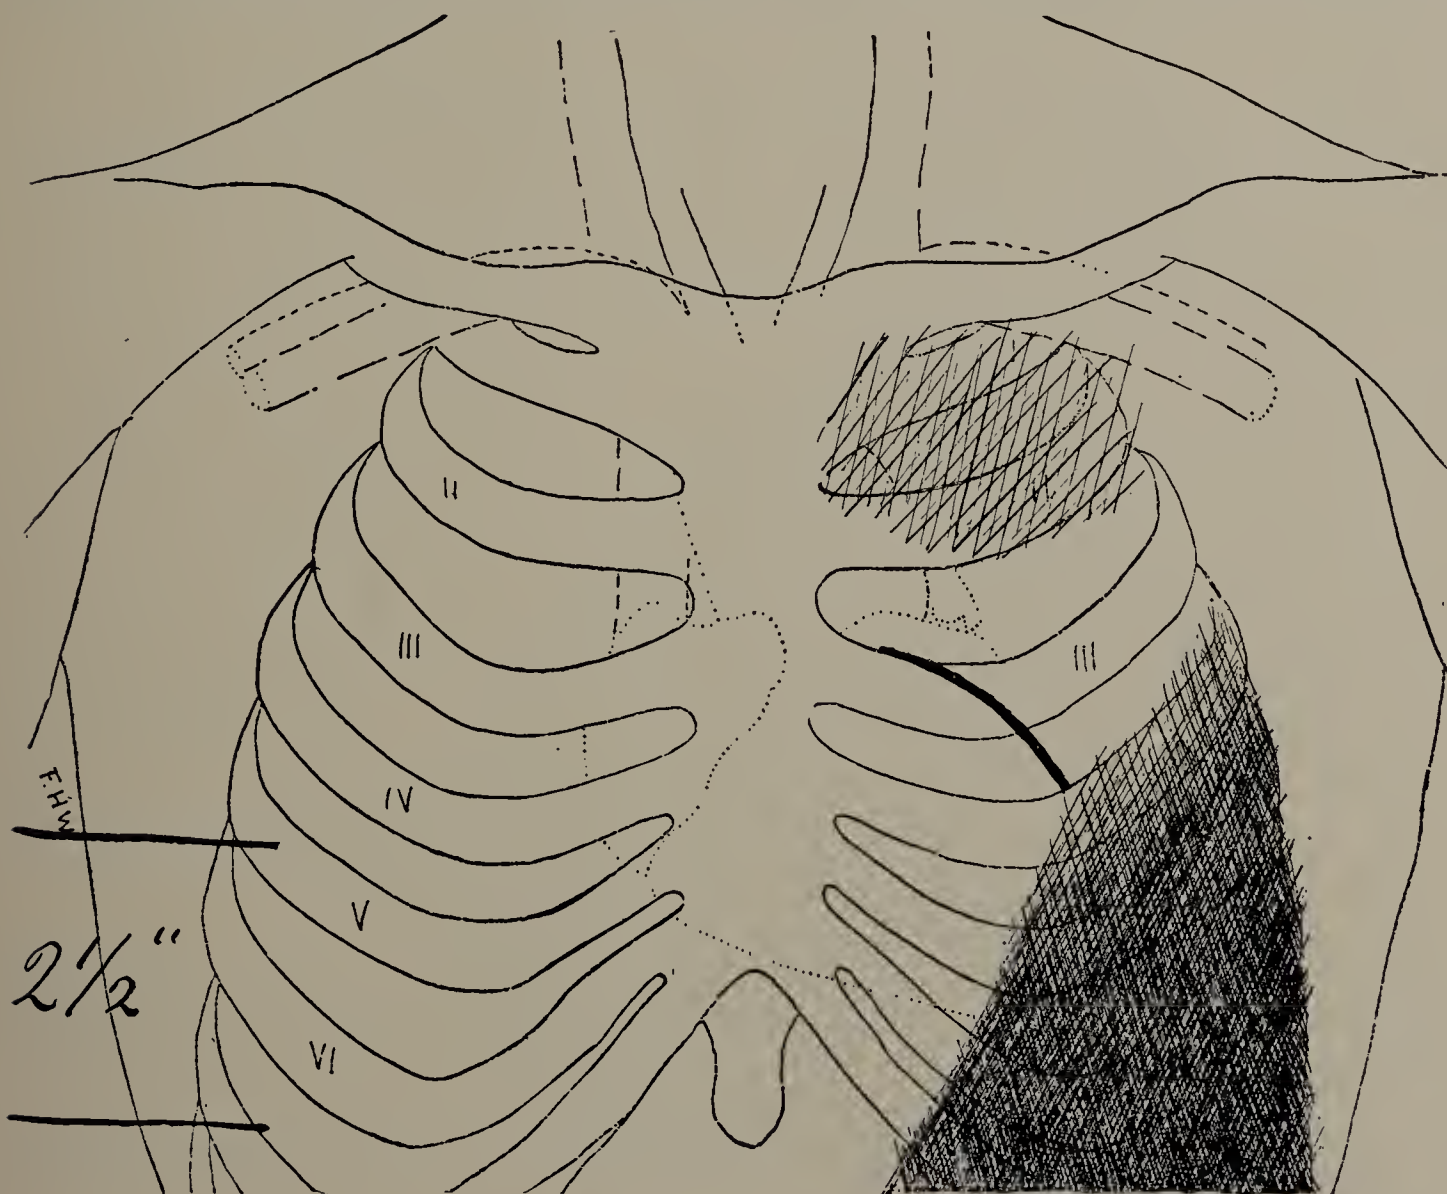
Mary F. May 18. Third X-ray examination with screen. Still less fluid in left chest. Light area between tuberculous left apex and fluid is larger. A portion of the left border of the heart can now be seen. Excursion of diaphragm on right side 6.3 centimetres. (Cut one-third life size.)
